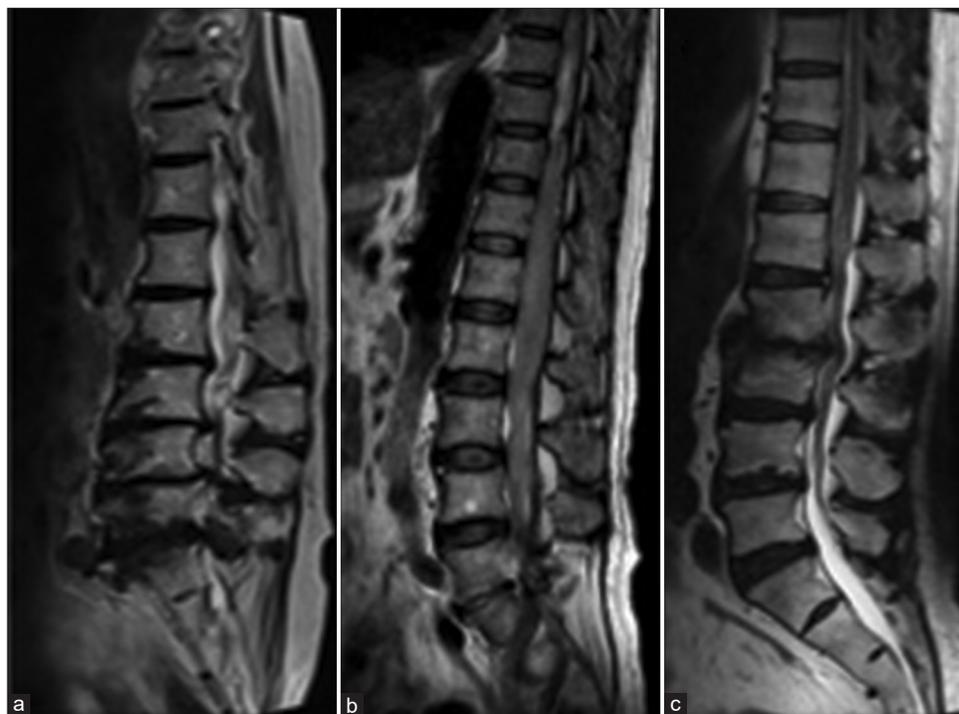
T2-weighted sagittal images show a typical case of redundant nerve root (RNR) (a) and a case of malignant lymphoma (b). Comparing these images, it is clear that the MR findings in this case (c) are more similar to those of spinal tumor than to those of typical RNR, although the degree of enlargement of the cauda equina is different.
